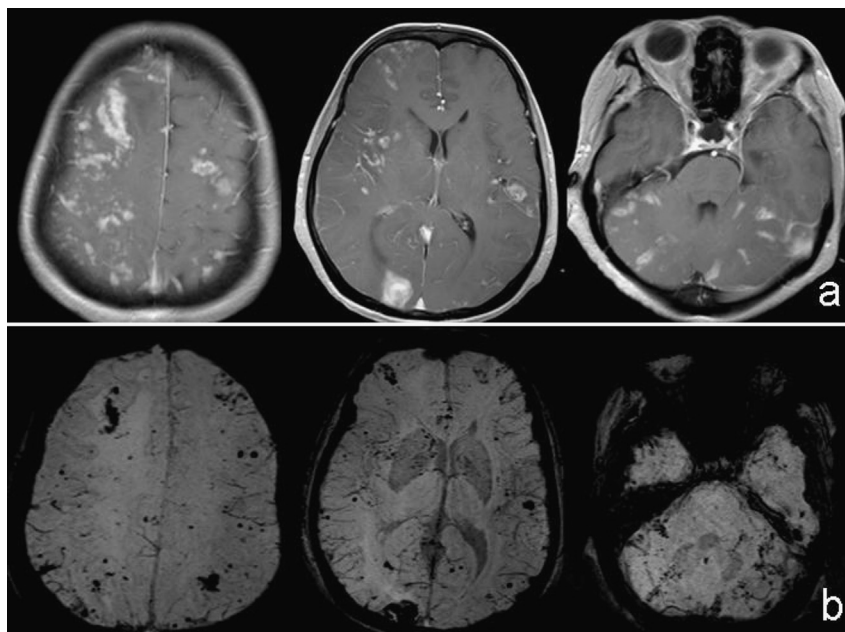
Follow-up MRI on 4th day of admission showed diffuse nodular and circular contrast enhancements involving the whole brain (3a) and diffuse dotted and patchy low signal intensity on SWI which indicated the diffuse micro-abscesses and micro-hemorrhages (3b).
